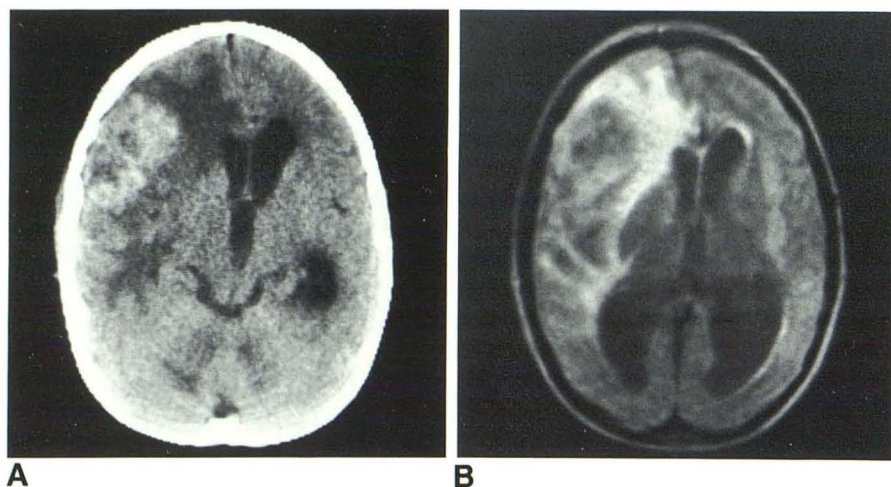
Case 1. A, Contrast-enhanced CT scan shows frontoparietal hypodense mass with perifocal edema. B, MR image (SE 1580/80) displays edema as light areas surrounding lesion.
